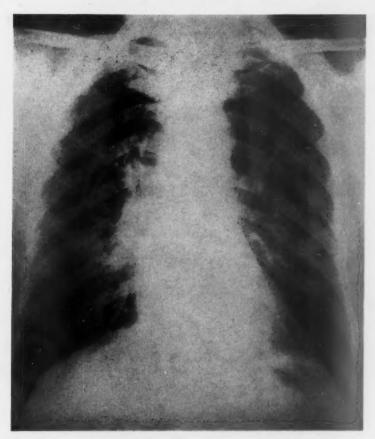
Case 13. Repeat posteroanterior chest x-ray, 10/16/53. X-ray report: "The infiltrations throughout both lung fields have cleared up considerably...some fullness in both hilar regions... remainder of the lungs is relatively well aerated... the cardiac silhouette is normal."
